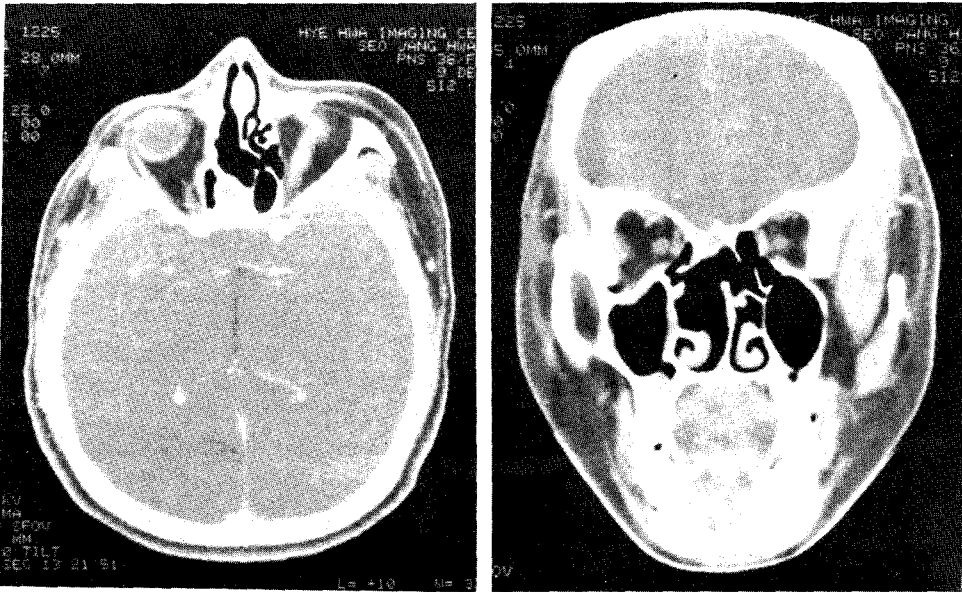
Follow-up PNS CT scan after 10 months of postoperative radiotherapy revealed no evidence of recurrence.
